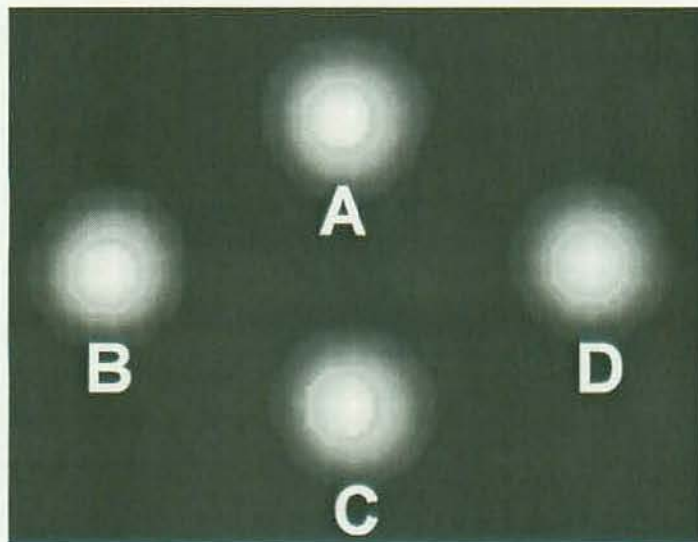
Attenuation-corrected SPECT image by using low-current CT images ($SPECT_{CT10}$).
